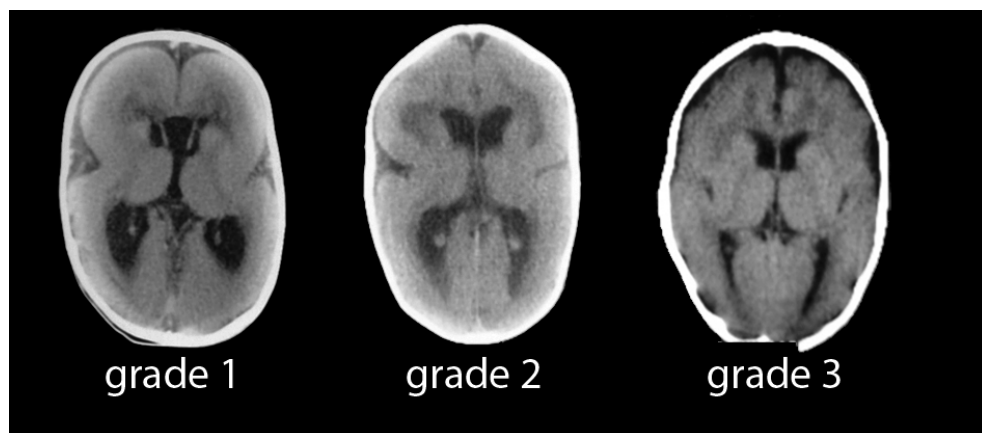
examples of CT scans and grading. Grade 1 (patient 24, female, CT scan made at the age of 9 months) shows complete agyria, 'figure of eight'-configuration due to lack of opercularization and thickened cortex. Also note the cavum septum pellicidum. Grade 2 (patient 17, male, CT scan made at the age of 4.5 months). Note the few shallow sulci in the frontal lobes and some opercularization. Grade 3 (patient 4, male, CT scan made at the age of 1 yr). Note diffuse course gyri and shallow sulci predominantly in the anterior regions and the further opercularization of the insular region.
